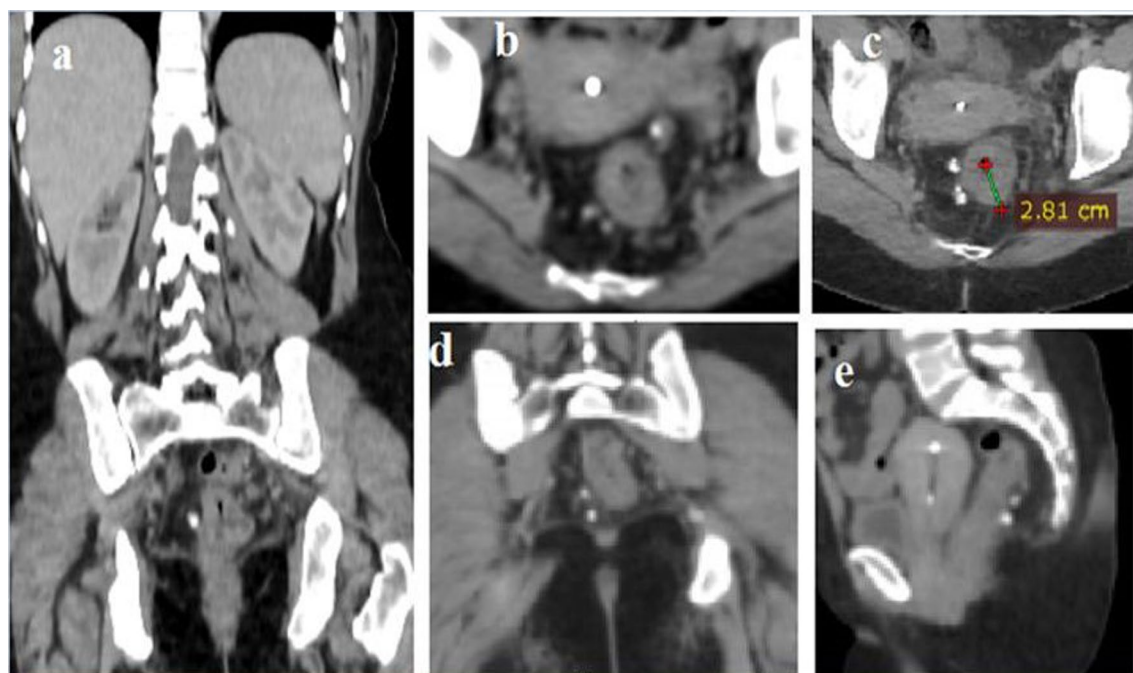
a–e Follow-up Post contrast CT study for the same patient in Fig. 4. a–e coronal, axial and sagittal images revealed: slight progression of the rectal disease process regarding the maximum thickness (2.8 cm, compared to 2.5 cm on the previous scan); (which could be pseudo-progression due to cystic or mucinous degeneration of the primary tumor; rather than actual viable tumoral progression, this considered a limitation of conventional CT alone). However, no appreciable size or number changes regarding the previously noted calcified LNs, confirming on viable nodal lesions
